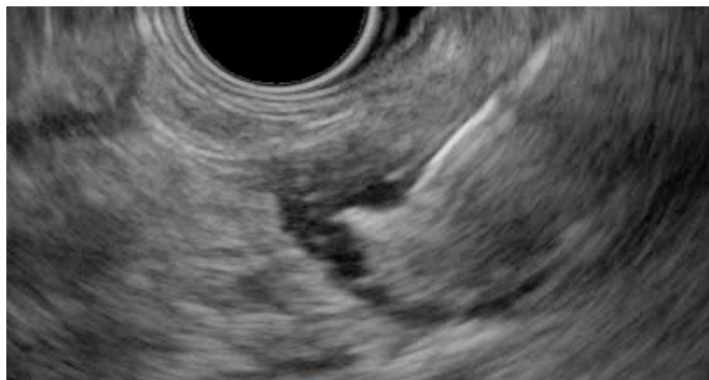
Endosonographic image of the microforceps opened within a pancreatic cystic lesion.
